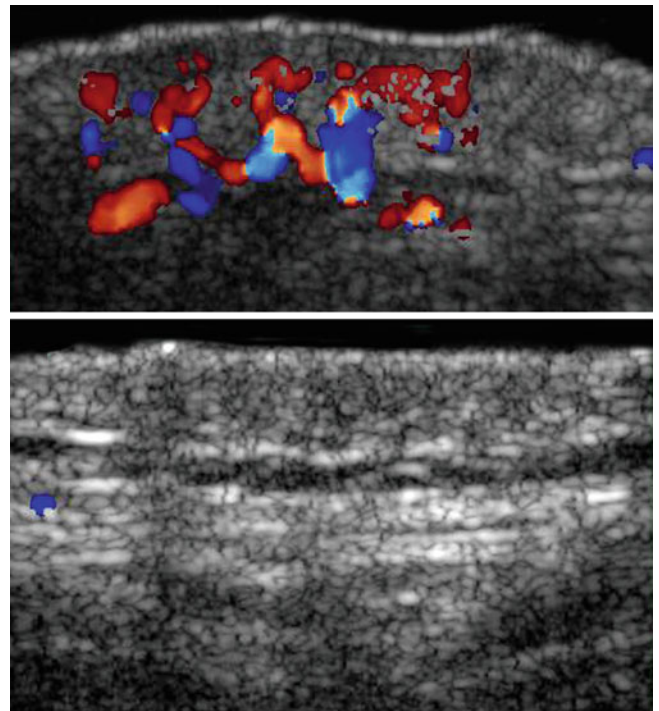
Grading of activity in morphea (color Doppler ultrasound image) going from active (*top*, hypervascular) to atrophy (*bottom*, hypovascular) phases
